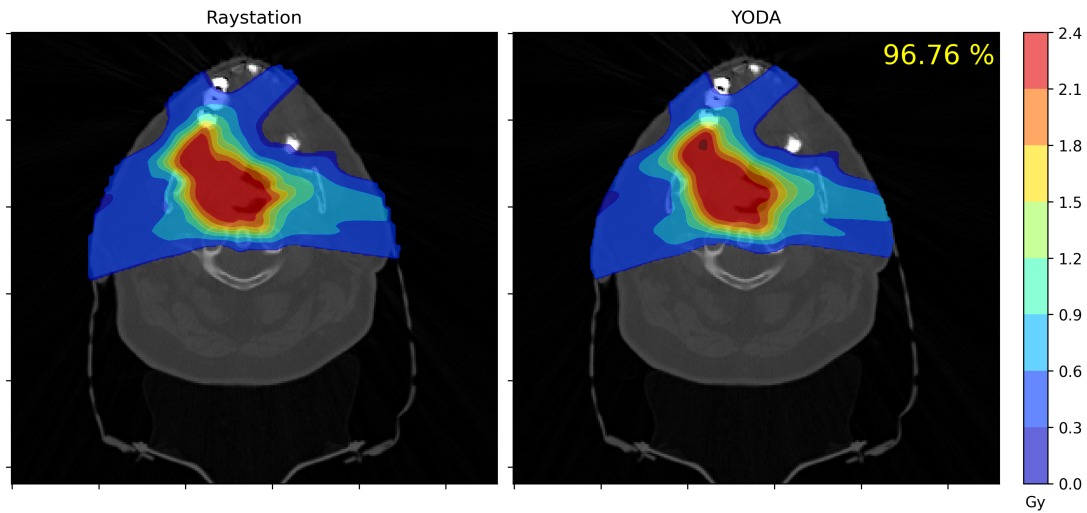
Dosimetric comparison between RayStation and YODA for the Patient 2. The figure displays RayStation (on the left) and YODA (on the right) two-dimensional dose cuts, overlaid on the corresponding CT slice. The figure displays in the top right corner of the YODA plot, the three-dimensional gamma index passing rate using 2 mm, 2% and 10% cut-off.
